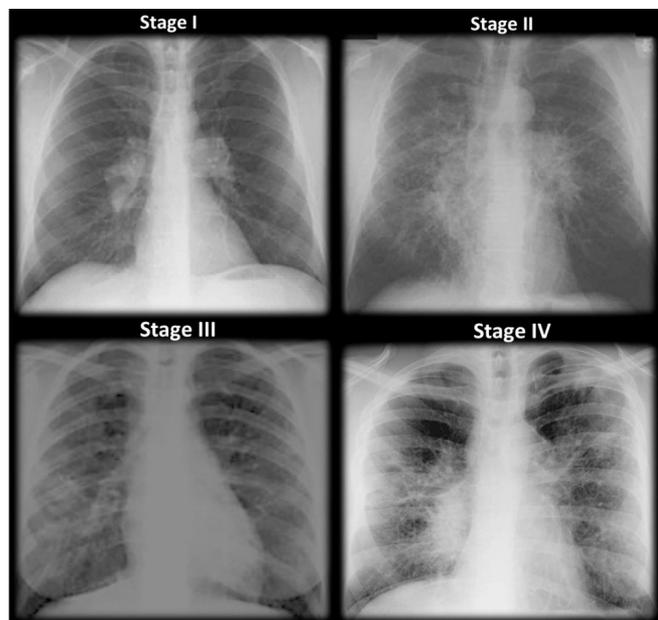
The four different stages of pulmonary sarcoidosis - From: Jara-Palomares et al. [8] *Staging of sarcoidosis on basis of chest radiographs*. Clinical Manifestations of Sarcoidosis. In: Eishi Y, editor. Sarcoidosis. This work is licensed under a Creative Commons Attribution 3.0 Unported License. © The Authors.
